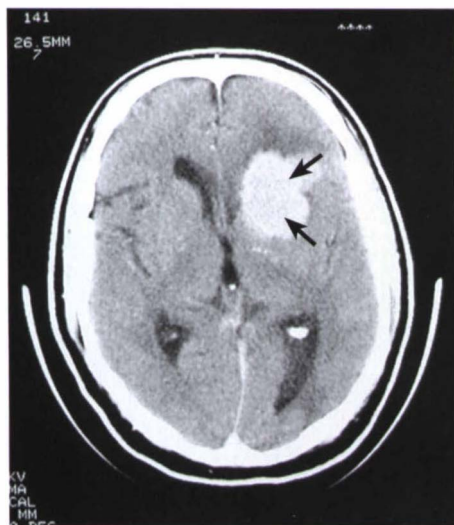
Postinfusion (C1) CT scan of the brain, demonstrating a tumor "highlighted" by the IV contrast material (arrows).
